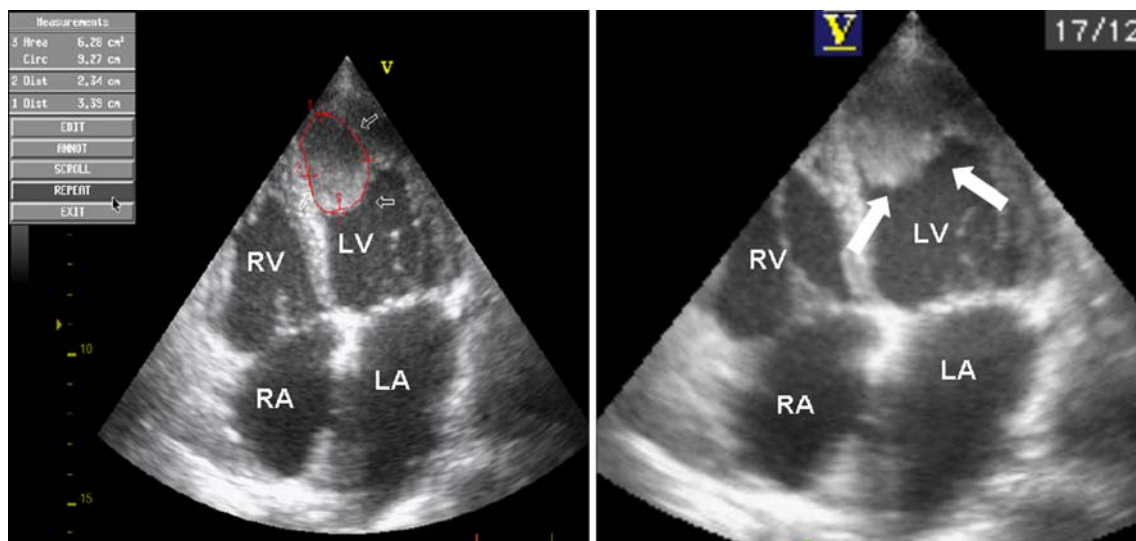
Echocardiographic four-chamber views presenting endocardial thickening together with a large mass (arrows) in the left ventricular apex, which was suggestive of a thrombus. (RV: right ventricle, LV: left ventricle, RA: right atrium, LA: left atrium).
